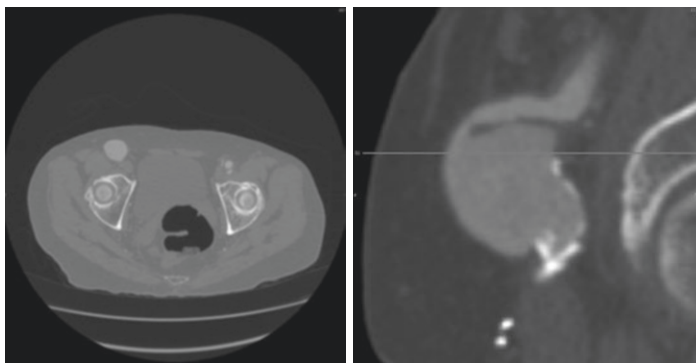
CT scan demonstrating right common femoral anastomotic aneurysm that had developed after Aortobifemoral bypass
